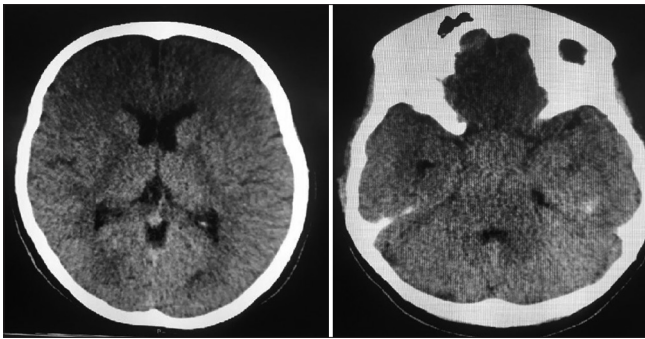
Computed tomography scan demonstrates no evidence of hydrocephalus
